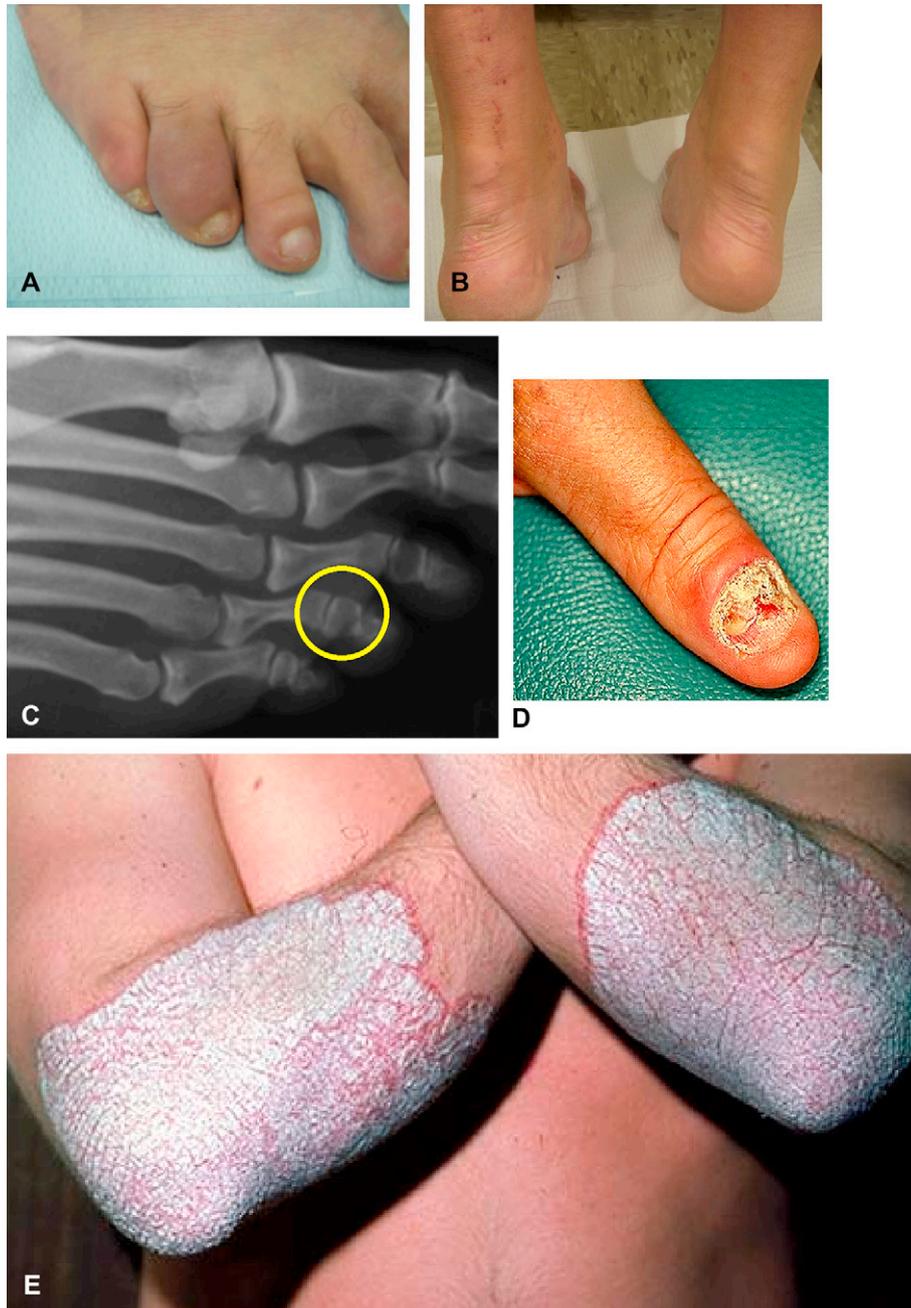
A to E, Patient with psoriatic arthritis. A, Dactylitis of 4th toe. B, Enthesitis of Achilles tendon. C, X-Ray of dactylitis of 4th toe. D, Severe nail dystrophy. E, Large discoid plaques on elbows.
